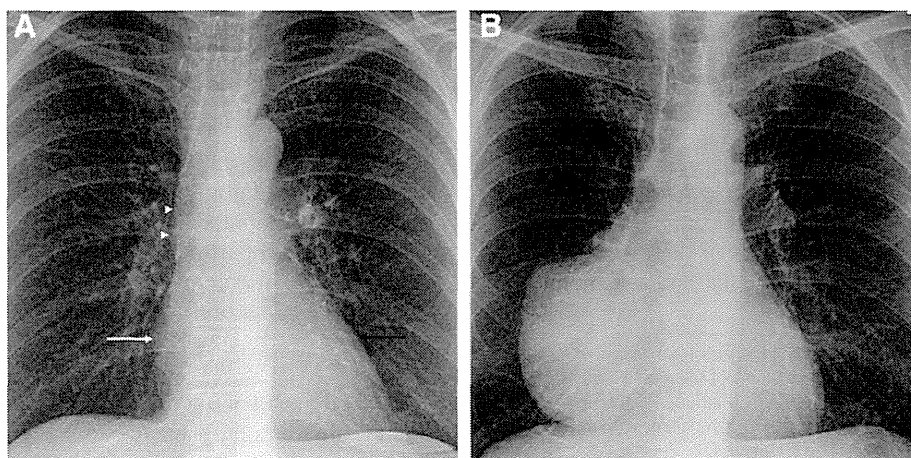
Normal anatomy and the silhouette sign. A, Coned-down posteroanterior chest radiograph demonstrates the normal boundaries of the anterior mediastinum: the right heart border (white arrow), left heart border (black arrow), and ascending aorta (arrowheads). These structures are normally visible on chest radiography because they are delineated by air-filled lung. B, Coned-down posteroanterior chest radiograph of a different patient demonstrates obscuration of the right heart border and ascending aorta by a large right anterior mediastinal mass found to represent lymphoma at the time of surgery. This loss of normal boundaries and structures, known as the silhouette sign, may be used to localize an abnormality to a specific mediastinal compartment such as the anterior mediastinum in this case.
